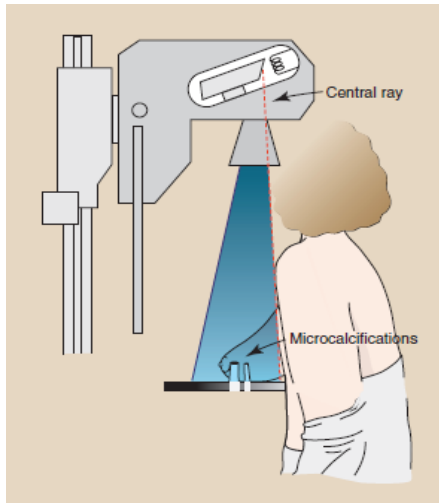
Shows the effect of the X-ray tube tilting inside the tube assembly (Bushong, 2013).
